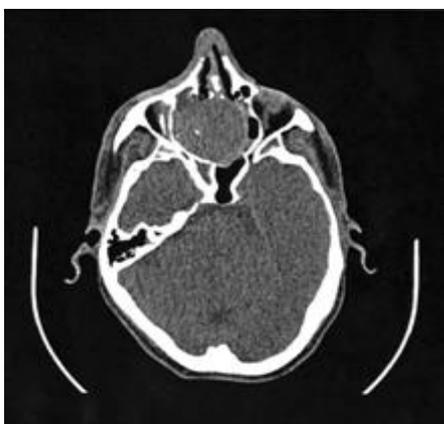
Axial CT scan nose and PNS showing right nasal mass extending into paranasal sinuses
